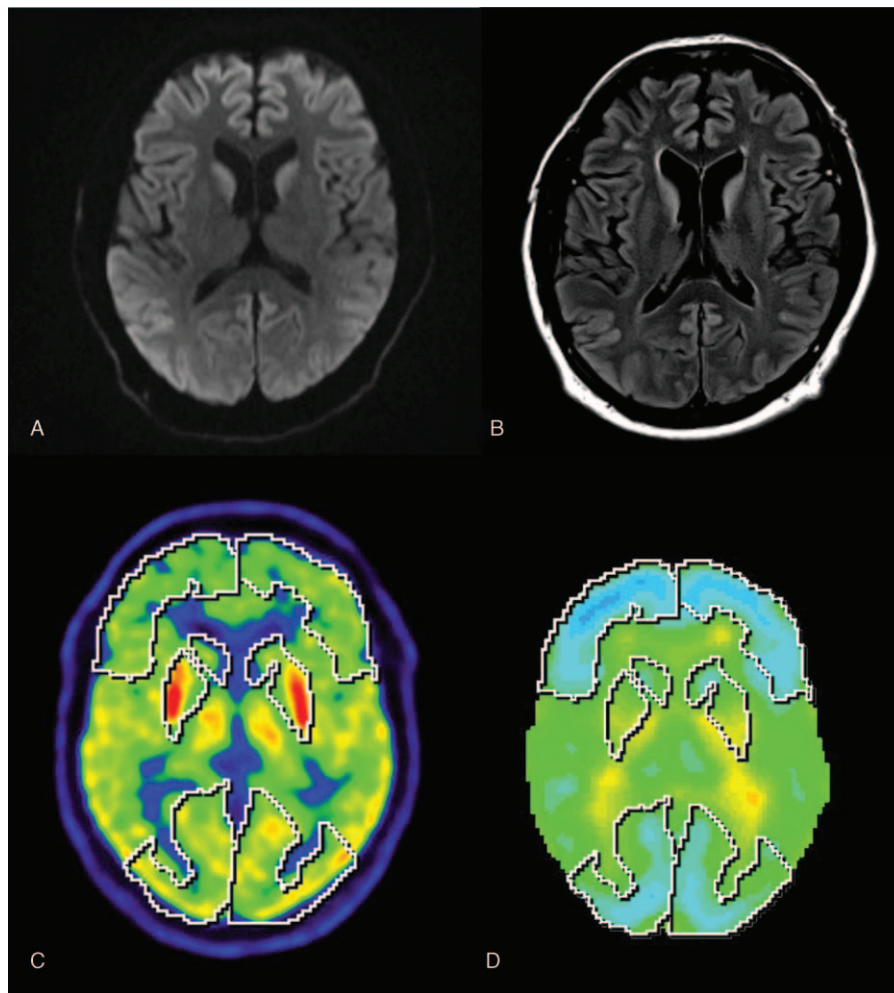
A–D: Brain MRI (A + B): Diffusion-weighted images b1000 (A) and FLAIR (B) at the level of the basal ganglia show mildly restricted diffusion and FLAIR hyperintensity, respectively, bilaterally in the caudate nuclei as well as in the frontal cortex, parietal cortex, and cingulate gyrus. Brain FDG-PET (C + D): A transaxial section at the level of the basal ganglia (C) demonstrates decreased uptake in the frontal and occipital cortex, moderately decreased uptake in caudate nuclei, as well as enhanced uptake bilaterally in the putamen. Significant metabolic changes as compared with the normal references (SD) are shown by semi quantitative VOI-based analysis (D). FDG, fluorodeoxyglucose (^{18}F).
